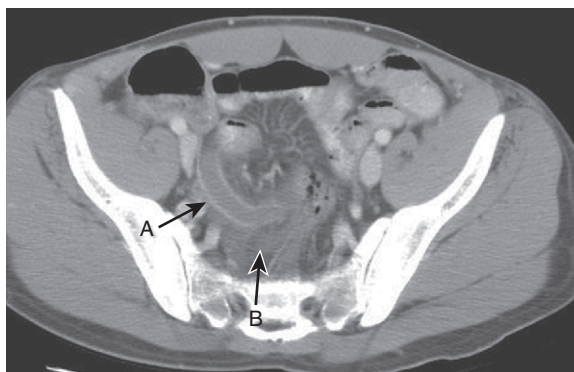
Diverticulitis. Computed tomography (CT) image demonstrates thickened wall of the sigmoid colon (arrows) with stranding in the adjacent fat (*). (From McNally PR: *GI/Liver Secrets Plus*, 4th ed. Philadelphia, Mosby, 2010.)
